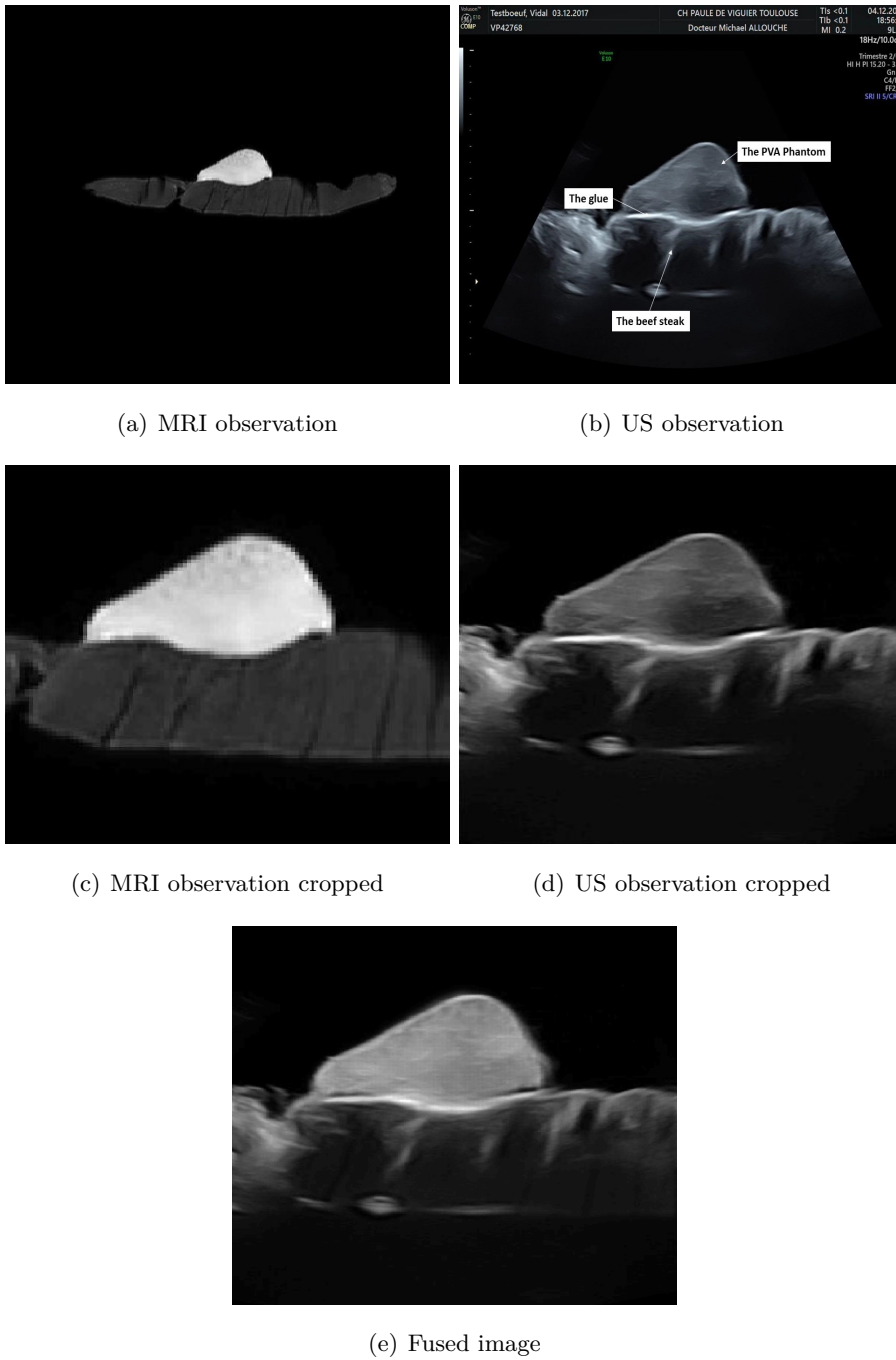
Image fusion results. (a,b) Full view and cropped MR images, (c,d) Full view and cropped US images, (e) fused image with the proposed method.
